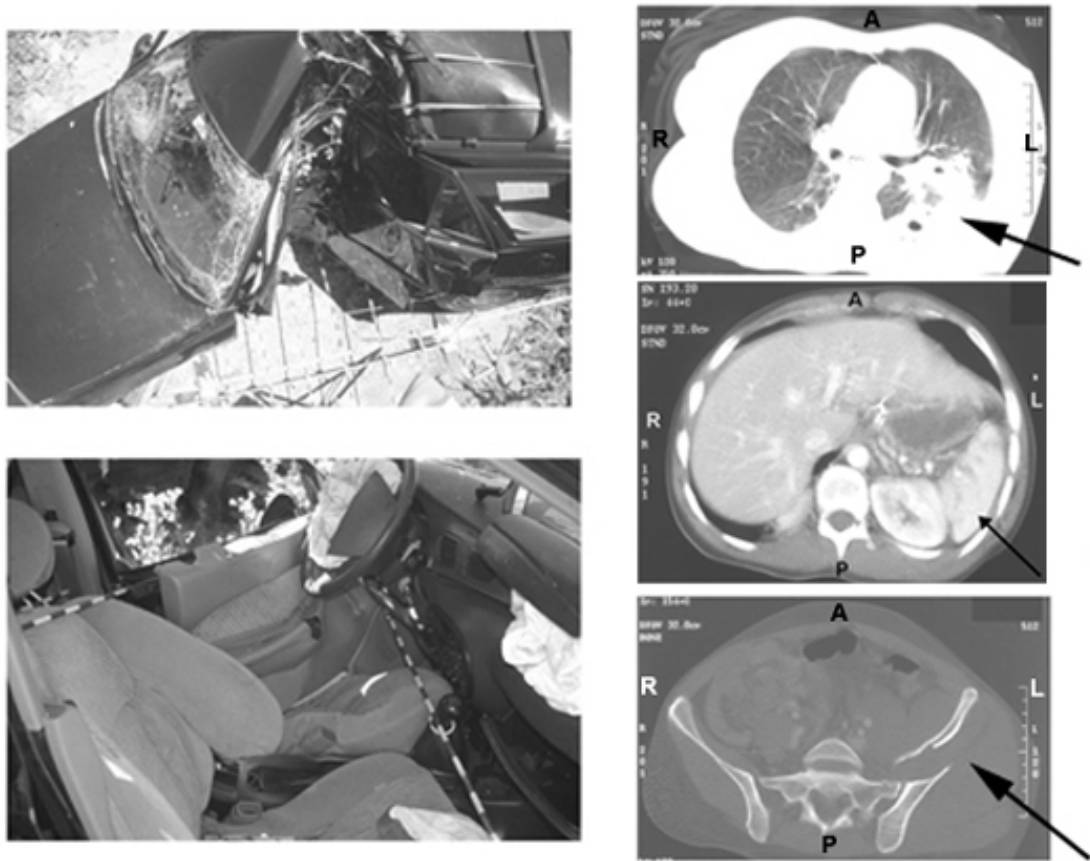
Lateral impact CIREN case. Photos on left show the exterior and interior vehicle damage. Case occupant CT scan image at the level of the lower chest (top right) shows a left posterior pulmonary contusion. CT scan image at level of the upper abdomen (mid right) shows injury to the spleen; image at the level of the pelvis (bottom right) shows an iliac wing fracture.
